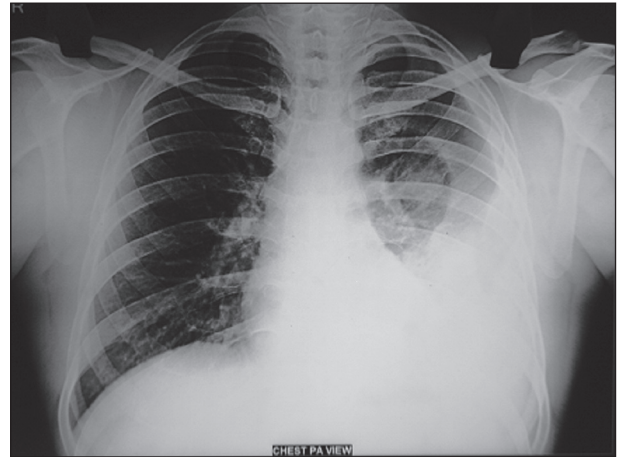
Chest radiograph shows inhomogeneous opacification of left lower and middle zone and obliterated left costophrenic angle and left dome of the diaphragm is suggestive of left sided pleural thickening with pleural effusion
